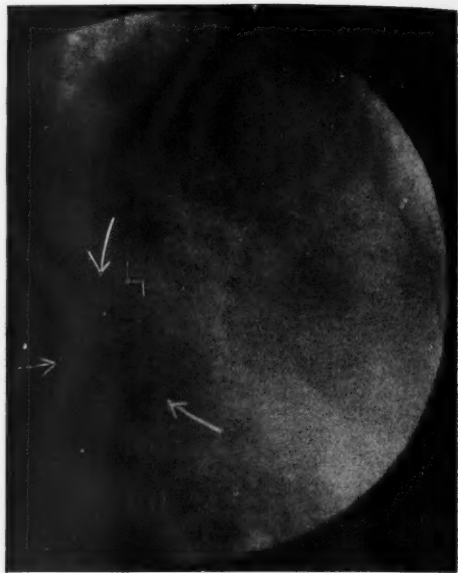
Radiograph made before operation, showing circumscribed areas of density in gall-bladder area which were thought to be gallstones.
